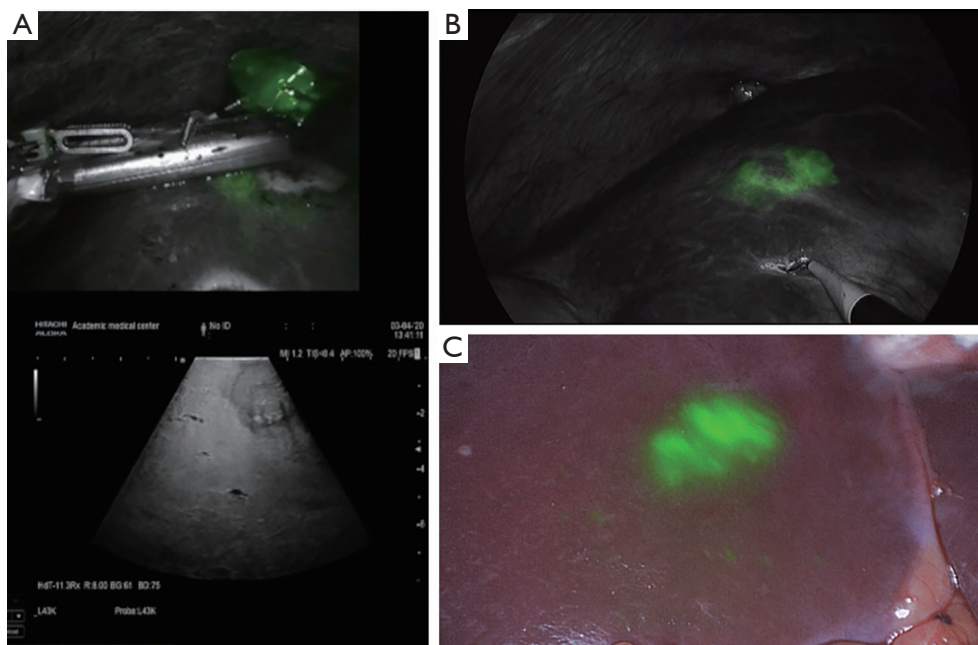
Two images of fluorescent enhancement patterns surrounding CRLM. (A) Typical rim-shaped enhancement pattern of capsular CRLM with simultaneous IOUS guidance; (B) rim-shaped fluorescent enhancement pattern surrounding a capsular CRLM; (C) circular-shaped enhancement pattern of subcapsular CRLM. CRLM, colorectal liver metastasis; IOUS, intraoperative ultrasonography.
